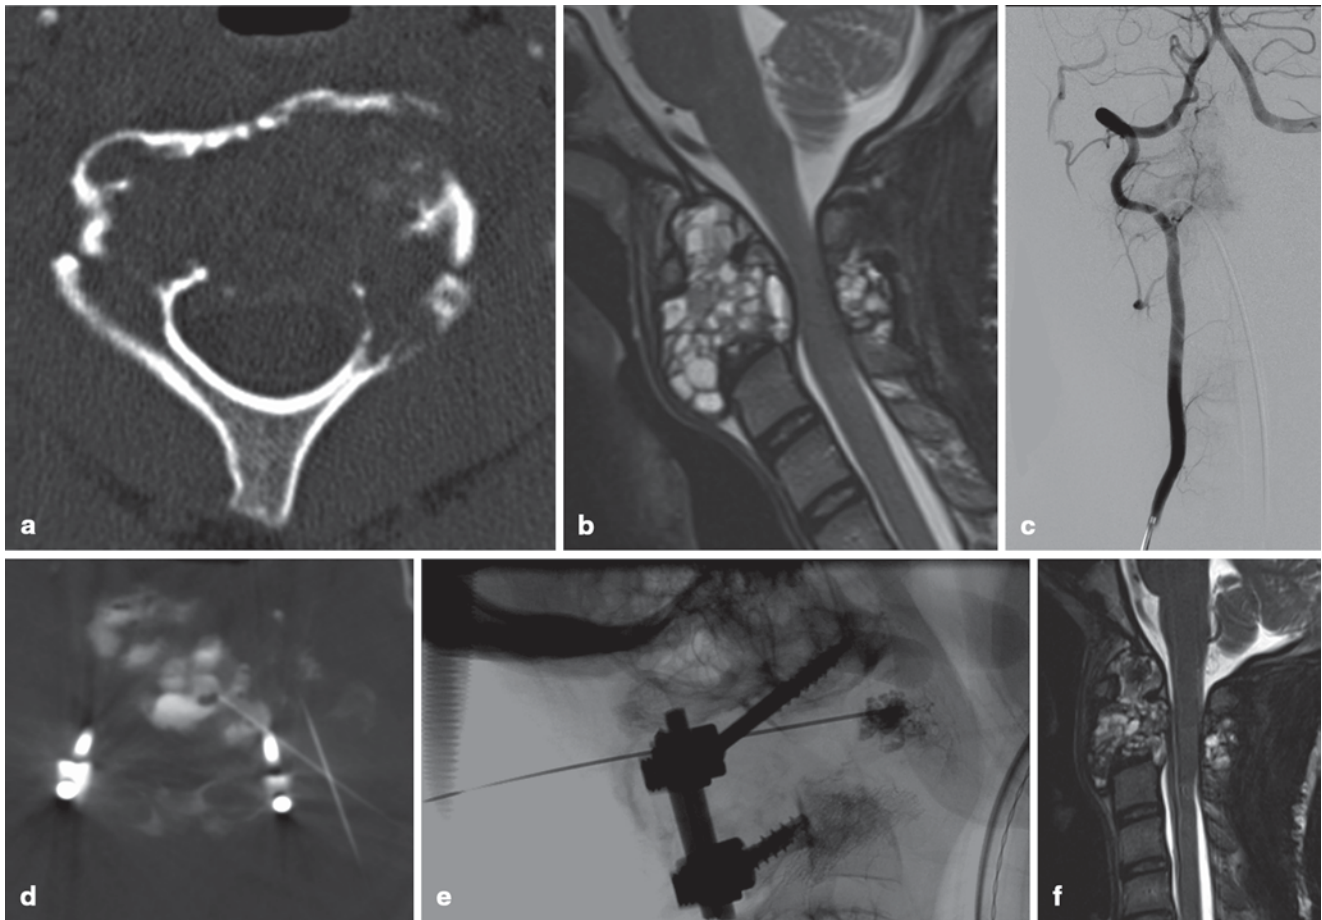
Aneurysmal bone cyst of C2: a Axial CT demonstrating large expansile, lytic mass involving most of the body of C2. b Sagittal T2-weighted MRI demonstrating the multicystic nature of the lesion with some mass effect on the anterior spinal canal. c Right vertebral artery arteriogram demonstrating a small amount of vascularity. d dynaCT
